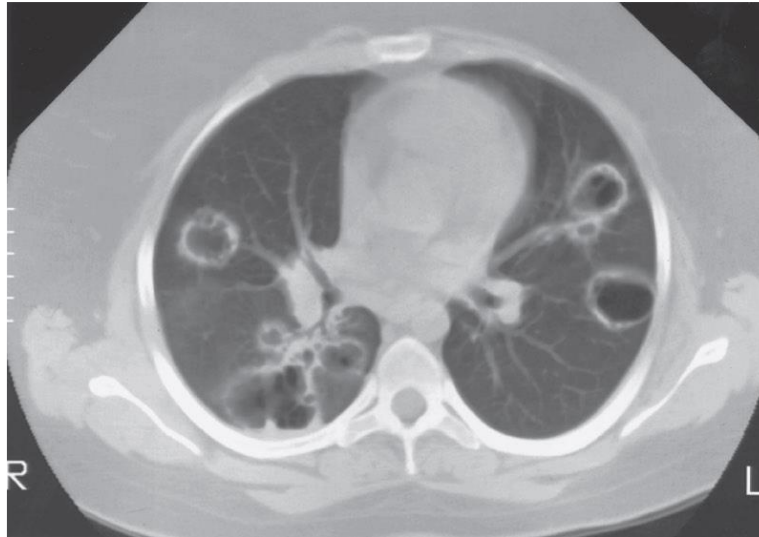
CT scan of a patient with granulomatosis with polyangiitis
